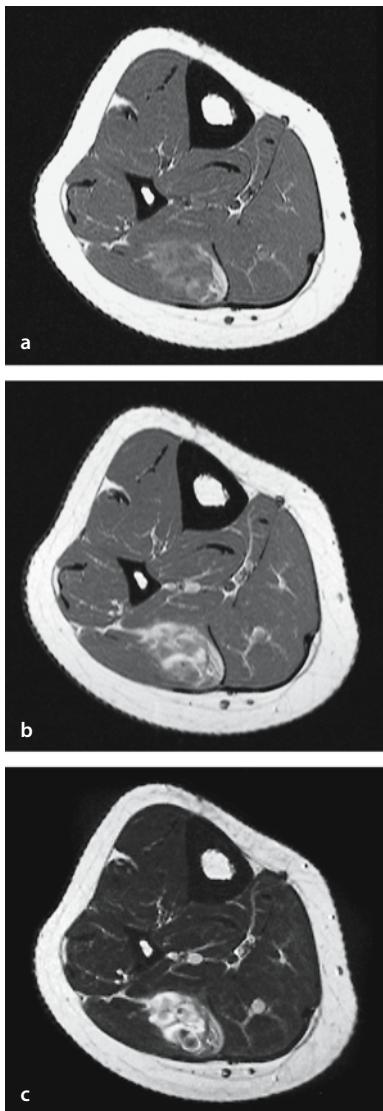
a–c. A 27-year-old man presenting with a painful swelling of the right calf. a Axial T1-weighted MR image. b Axial T1-weighted MR image after gadolinium contrast injection. c Axial T2-weighted MR image. An ill-defined, inhomogeneous mass within the lateral head of the gastrocnemius muscle is seen. The mass has a hyperintense medial border. The lateral part is nearly isointense to muscle (a). After contrast administration homogenization of signal intensity takes place due to a higher degree of enhancement of the low signal intensity parts on native T1-weighted images (b). The exact extent of the lesion, however, is still better appreciated on T2-weighted images (c)
